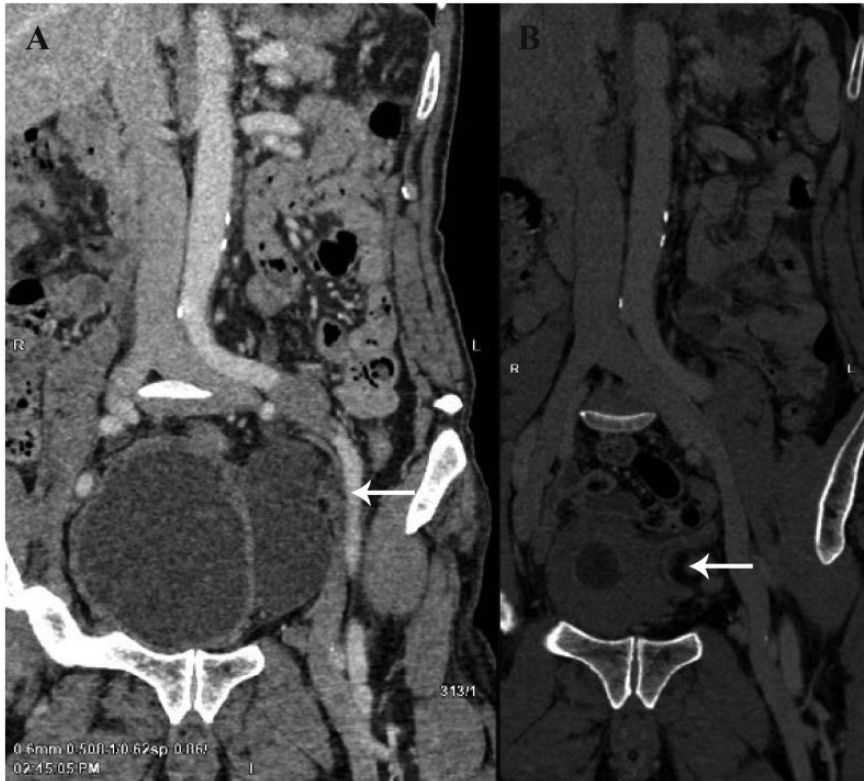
Representative computed tomography (CT) images of a 71-year-old male patient that presented with recurrent oedema of the left lower extremity for 6 years: (a) contrast-enhanced CT of the abdomen and pelvis showed a massive diverticulum of the bladder that resulted in severe compression of the left iliac vein (white arrow) and (b) CT re-examination indicated that the bladder diverticulum was obviously retracted and there was no compression of the left iliac vein (white arrow).
